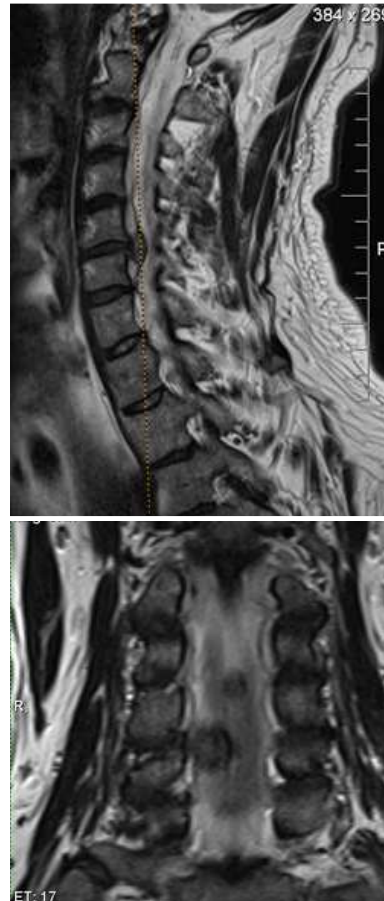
MRI scan: Right C4 – C5 herniated disc and median C5 – C6 disc herniation
